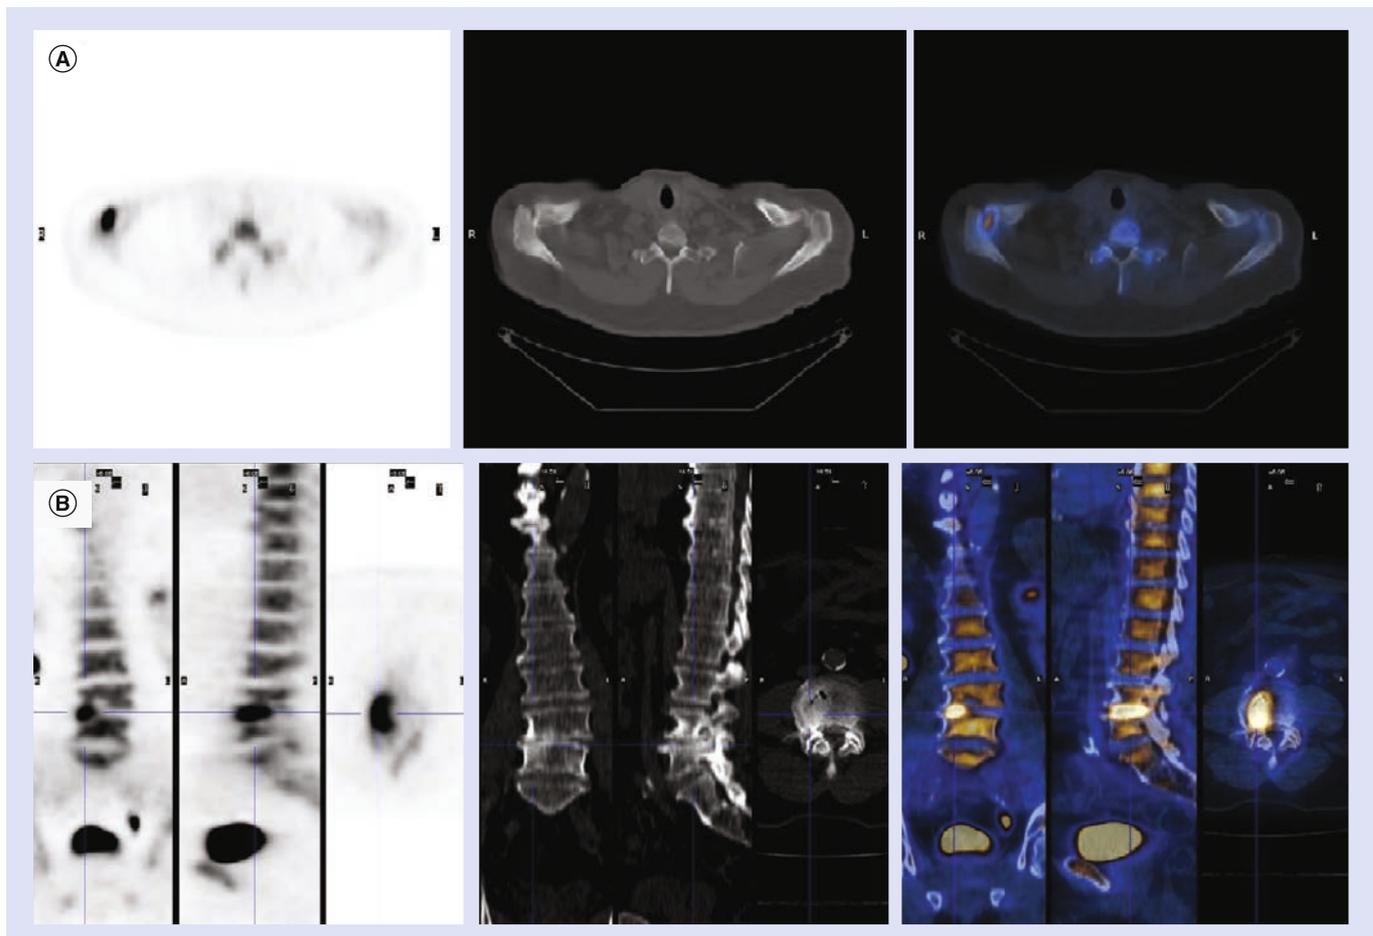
Na¹⁸F PET/CT in a 69-year-old male recently diagnosed with clear cell renal cell cancer and referred for skeletal staging. (A) Axial views of Na¹⁸F PET, low-dose CT and fused Na¹⁸F PET/CT show focally increased Na¹⁸F uptake at right acromioclavicular joint corresponding to arthrotic changes on CT. (B) Coronal, sagittal and axial views of Na¹⁸F PET, low-dose CT and fused Na¹⁸F PET/CT, show abnormal Na¹⁸F uptake at L4–L5 level on the right side, corresponding on low-dose CT to degenerative changes, including joint-space narrowing, an intradiscal fissure, retrolisthesis and anterior osteophytes.
